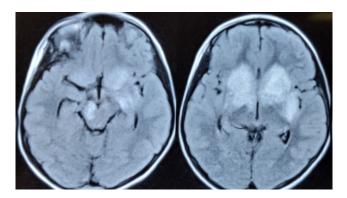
Axial Fluid attenuated inverse recovery sequence of brain magnetic resonance imaging showing hyperintensities in bilateral basal ganglia, right side of midbrain and left basi-frontal and left basi-temporal lobe.
